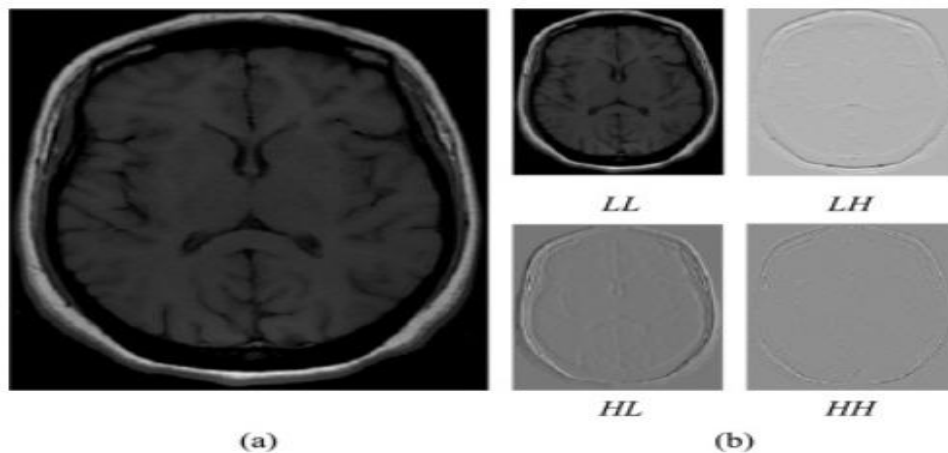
Image DWT decomposition; (a) Original T1-w MR image, (b) LL, LH, HL and HH sub-band images.
